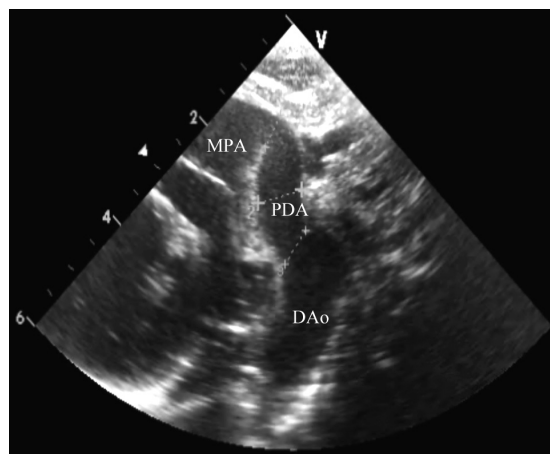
2D echocardiogram (ductal view) taken on Day 2 of life shows a large patent ductus arteriosus. MPA: main pulmonary artery; PDA: patent ductus arteriosus; DAo: descending aorta
